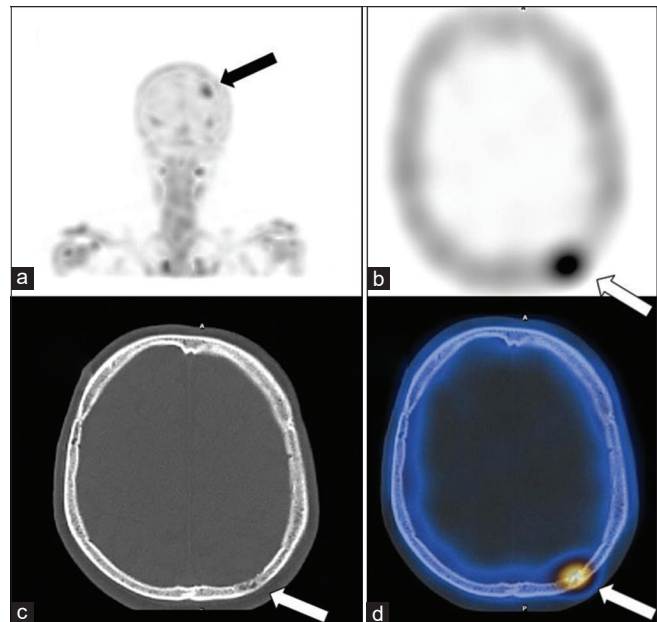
A 67-year-old man was diagnosed to have prostate adenocarcinoma (Gleason 7), with recent PSA level of 30.82 ng/mL. (a) Planar WBS and (b) SPECT imaging showed focal increased tracer uptake in the left posterior parietal skull bone (black arrow), (c) plain CT scan of the skull showed corresponding mixed lytic-sclerotic bone lesion (white arrow). (d) Fused SPECT/CT image localizing the radiotracer avid lesion at the left posterior parietal skull bone (white arrow), likely a bone metastasis. WBS: Whole-body bone scanning, PSA: prostate specific antigen, SPECT/CT: Single photon emission computed tomography/computed tomography
